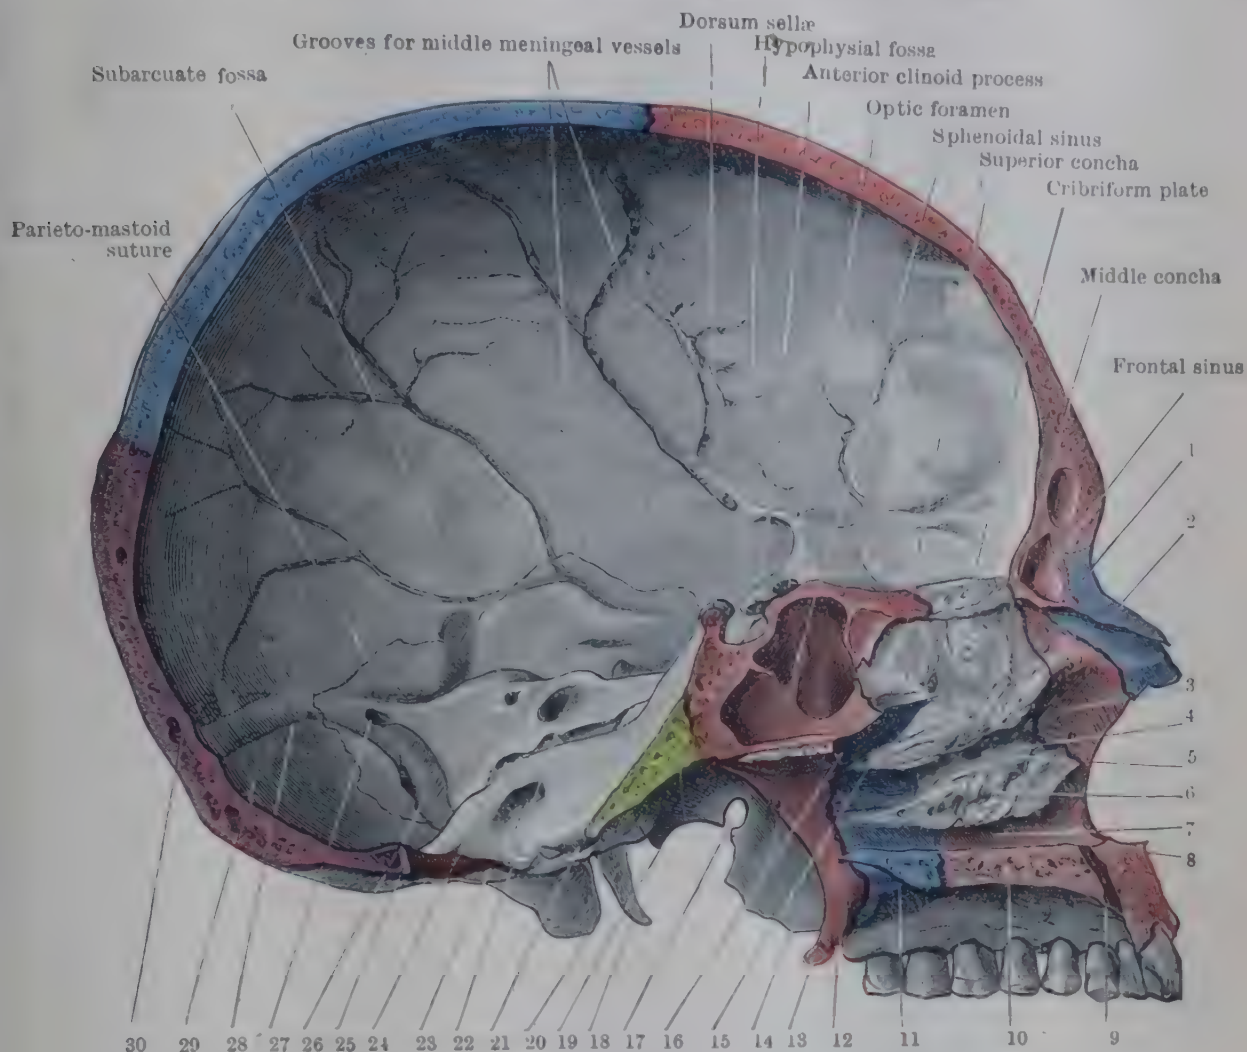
MEDIAL ASPECT OF LEFT HALF OF SKULL SAGITTALLY DIVIDED.
